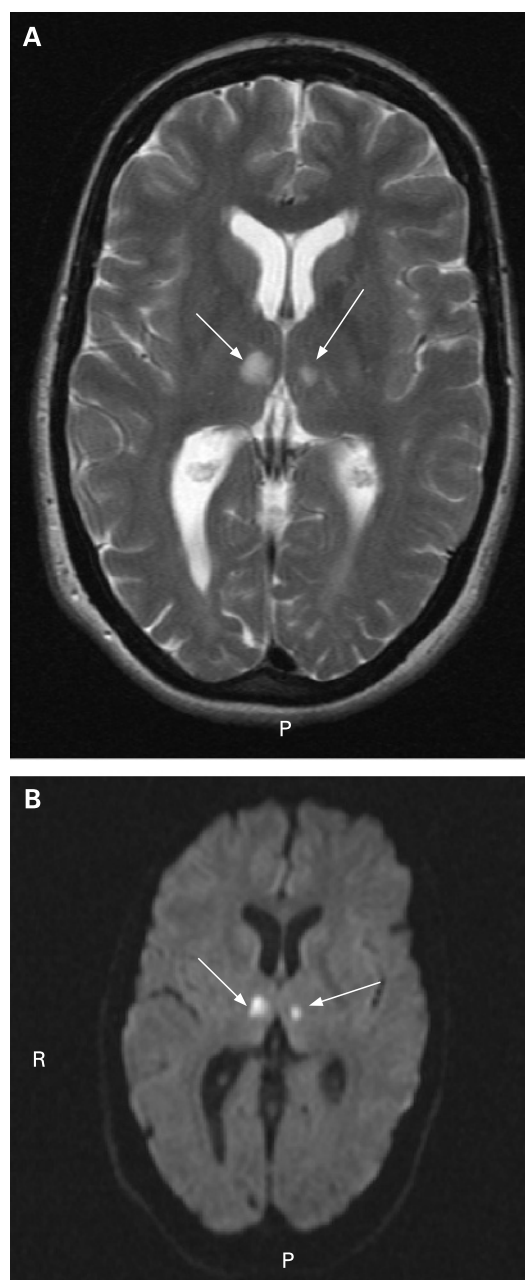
Brain MRI, showing bilateral paramedian thalamic infarcts (arrows) on (A) T2-weighted and (B) diffusion-weighted imaging.
